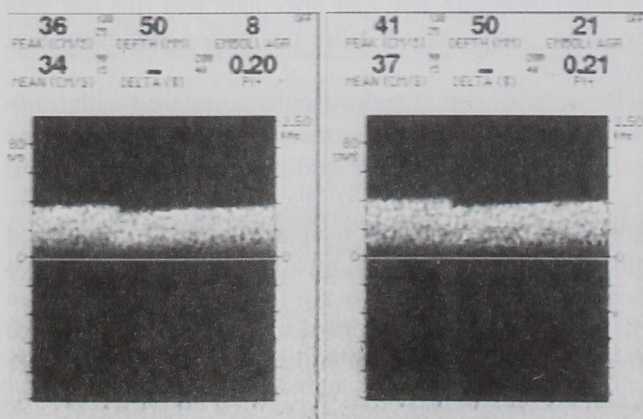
Normal transcranial Doppler image showing symmetrical flow through both middle cerebral arteries after the aortic balloon clamp was repositioned (moved proximally).
